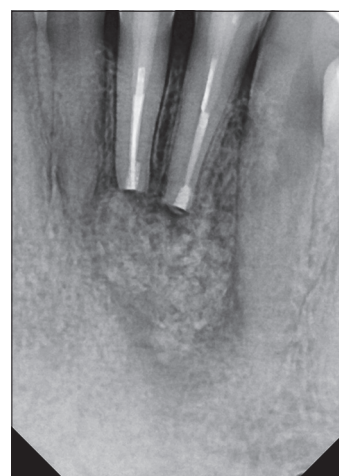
periapical radiograph immediately following the surgery to document the retrograde fillings in the two roots and fill of the defect with Bond Apatite®
